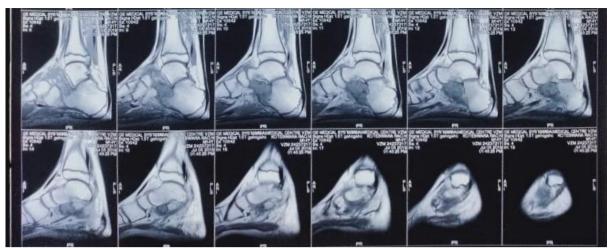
MRI sagittal cuts showing lesion in calcaneum.
